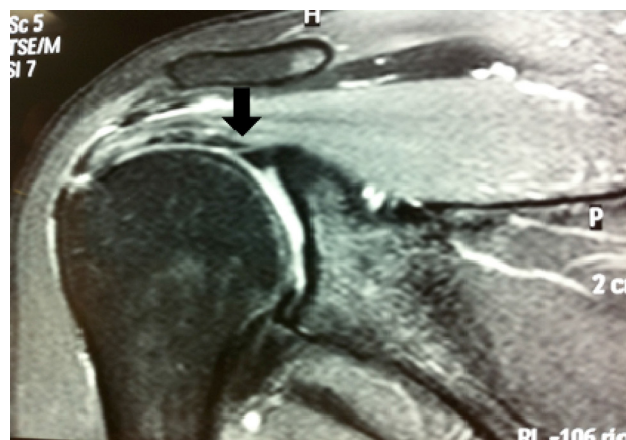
Coronal slice from magnetic resonance imaging, highlighting the anomalous origin of the long head of the biceps.
